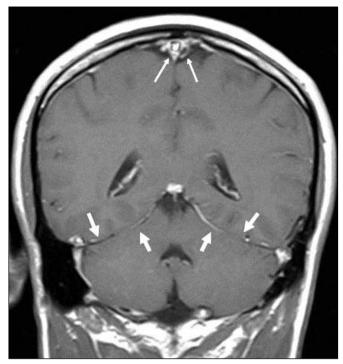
Contrast enhanced T1W Coronal MRI obtained one month after epidural blood patch (EBP) shows regression of tentorial enhancement and thickening (thick arrows). Venous distention also decreases with regard to previous MRI scan (thin arrows).
